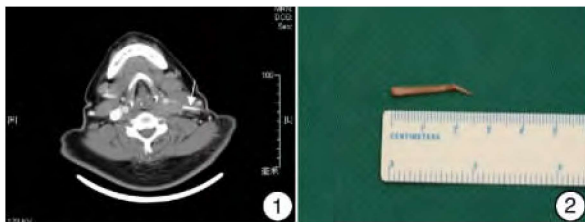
颈部增强 CT 示左侧颈部异物(箭头所示)并异物肉芽肿; 图 2 颈部探查术取出长约 2.4 cm 鱼刺一根
